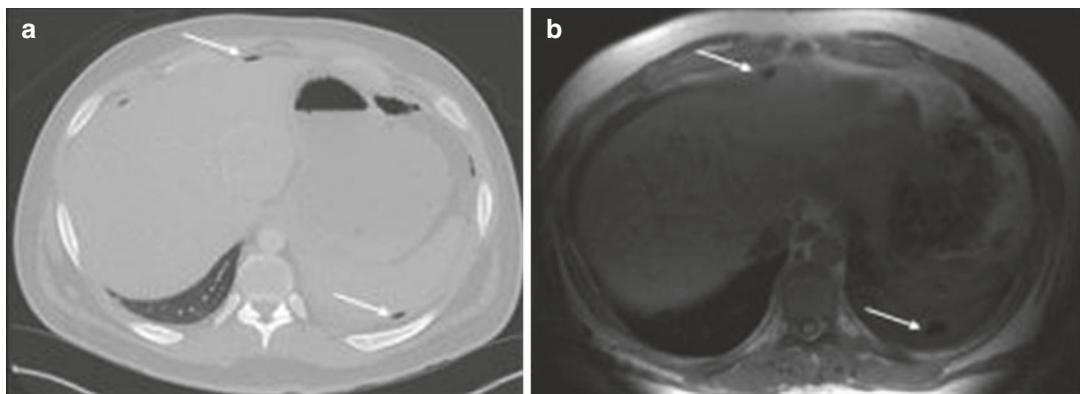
Free intraperitoneal air appears in the non-dependent abdomen of a supine patient. Axial abdominal CT image (a) utilizing lung windows shows multiple foci
